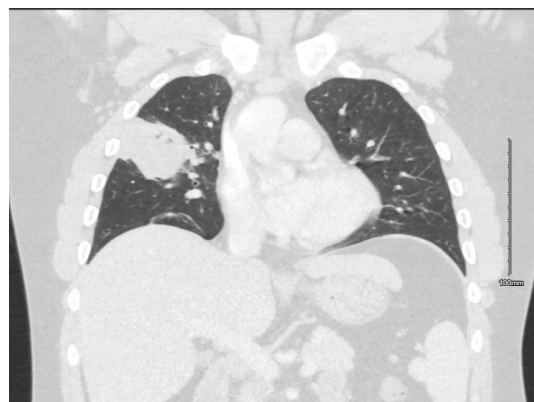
CT of the thorax on day three demonstrating a $80 \times 65 \times 40$ mm right upper lobe cavitating mass
